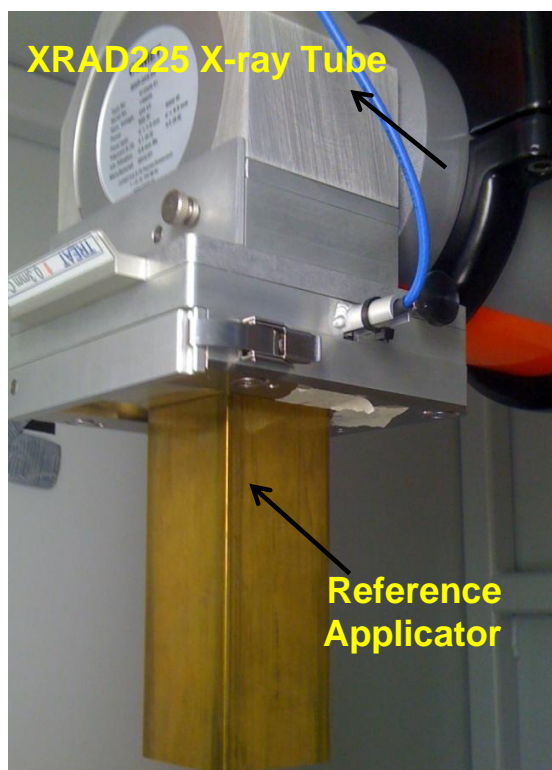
The MXR 225/22 x-ray tube inside the XRAD 225Cx irradiator enclosure
